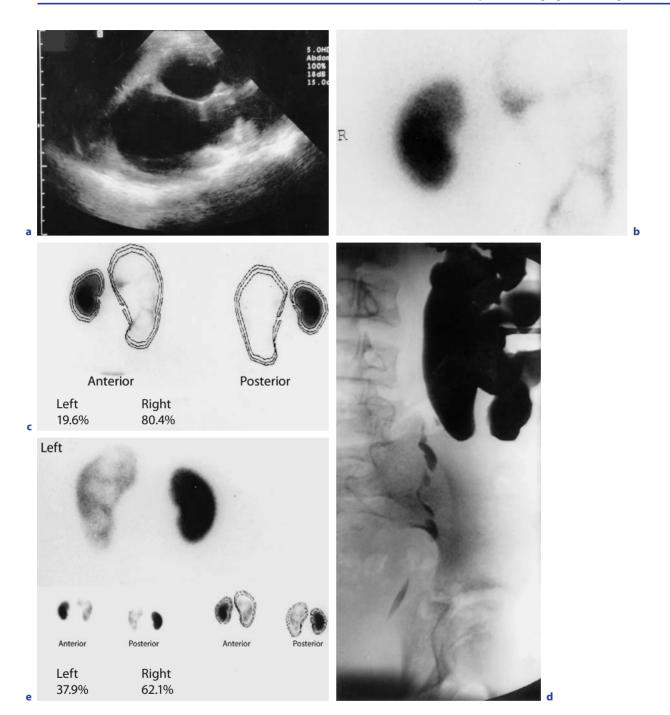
a Ultrasonographic examination shows very marked hydronephrosis with a thin cortical rim. b,c DSMA renal scintigraphy shows an enlarged left kidney with very thin rim of functioning renal tissue. The percentage uptake of the radiopharmaceutical on the left side is 19.6%. d Nephrostogram outlining a hydronephrosis with drainage down the ureter 4 weeks after nephrostomy drainage. e DMSA scan 4 weeks after nephrostomy drainage. There is an improvement in left kidney function to 37.91%
